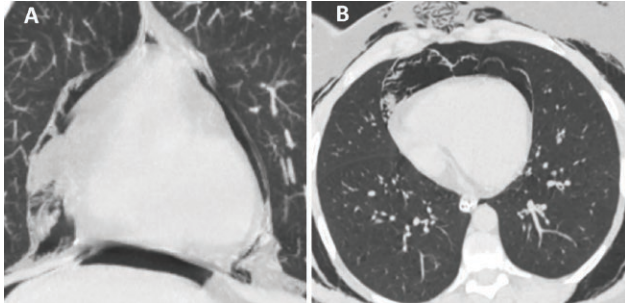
CT imaging demonstrating pneumomediastinum and pneumopericardium (A-B).
